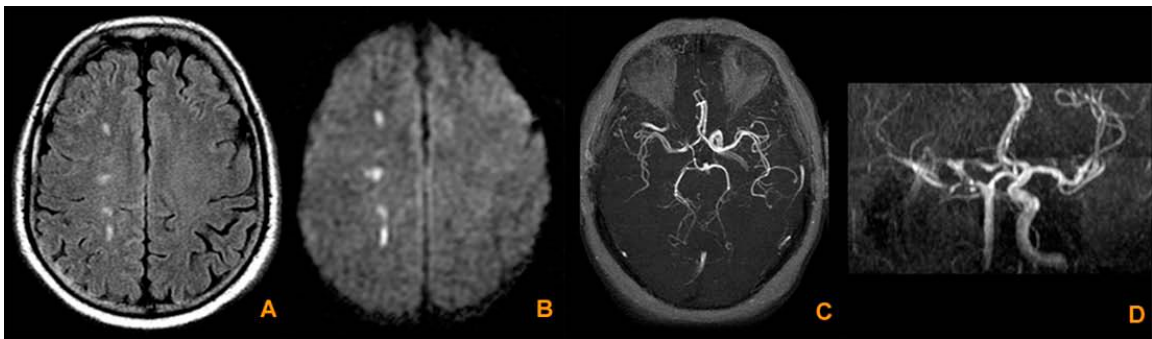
Cerebral perfusion MRI images taken from <http://emedicine.medscape.com/>
